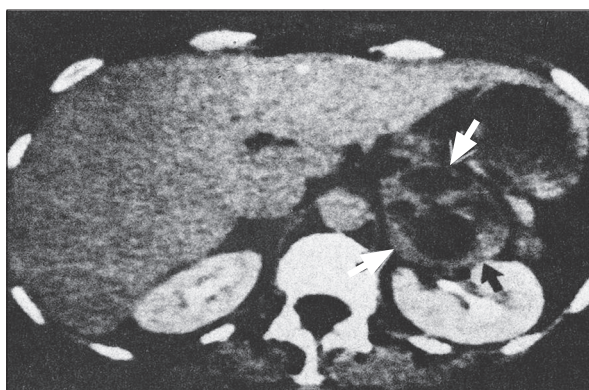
CT scan showing a large pheochromocytoma (left adrenal gland) (arrows).
